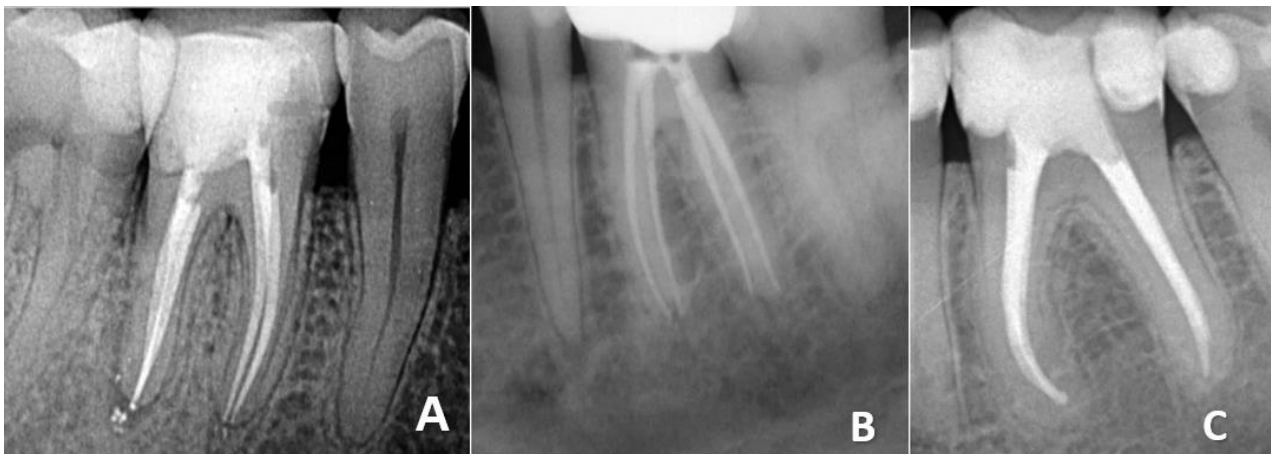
(A) Obturation to the anatomical apex but shorter than the radiographic apex, (B) obturation to the radiographic apex, (C) obturation with a visible sealer puff
